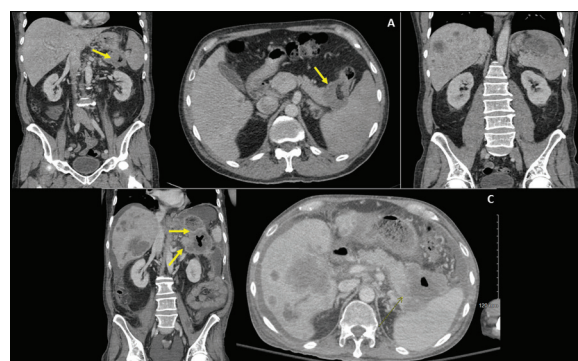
(A) Initial CT scan demonstrating proximal descending colon mass (indicated by yellow arrows) in coronal and axial section. (B) Initial CT scan demonstrating extensive hepatic and splenic metastases in coronal section. (C) CT scan demonstrating progression of primary tumor and metastatic disease despite systemic chemotherapy. Primary tumor now noted to invade the tail of the pancreas and spleen on this section.
